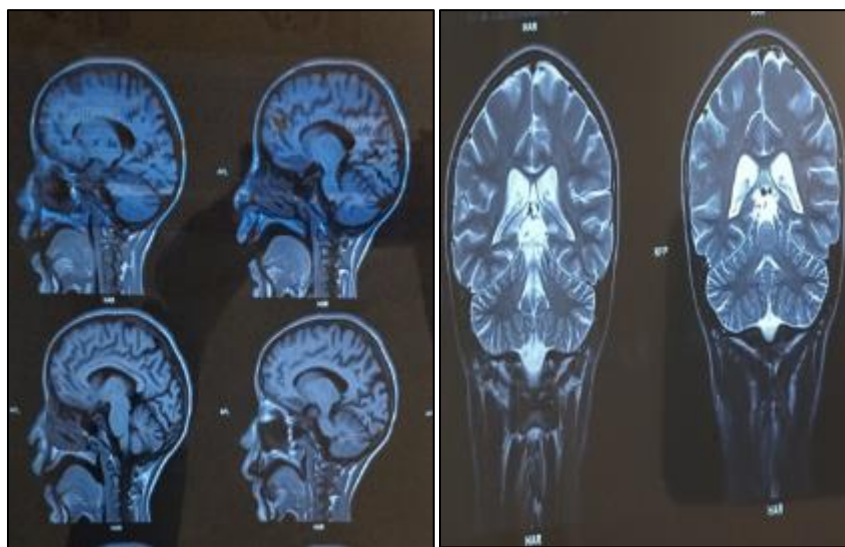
and 2 Brain MRI of the patient showing widening of the cortical sulci both supra- and infratentorial
